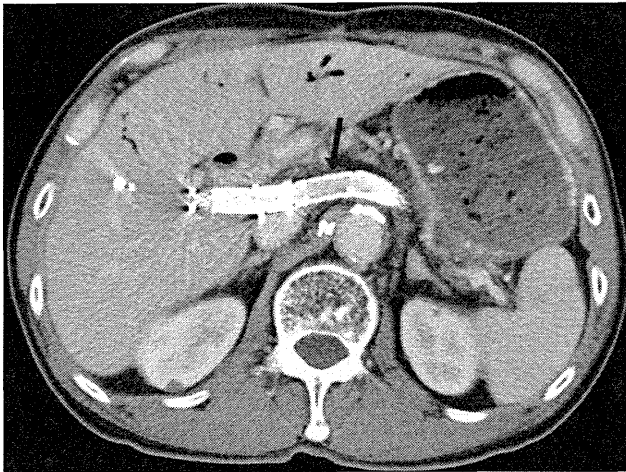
Axial contrast-enhanced CT at 10 months after the procedure. Stents in the splenoportal shunt are patent (arrow) and varices are decreased in size.
